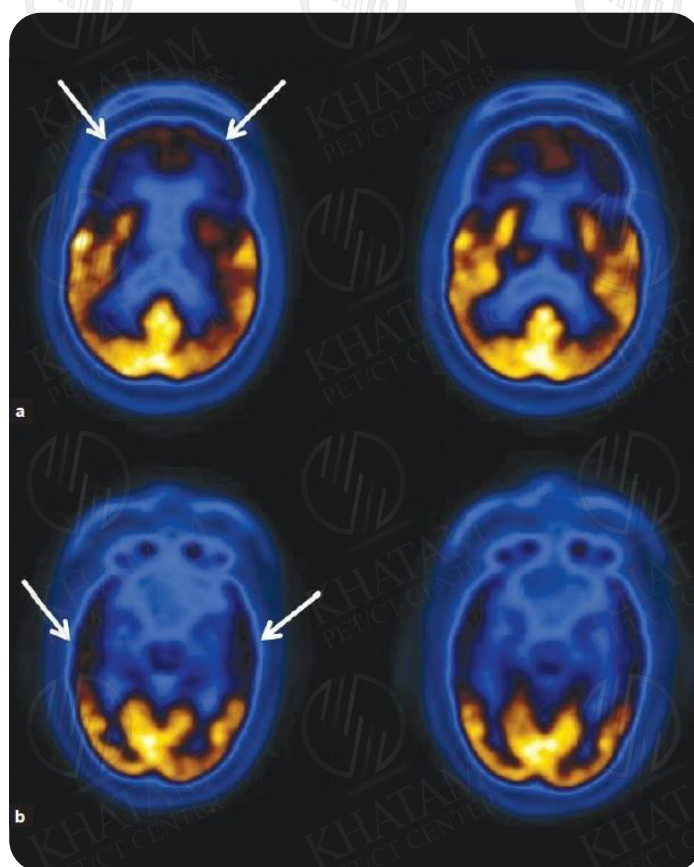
^{18}F -FDG PET images in a 55-year-old female with FTD. Arrows indicate bilateral hypometabolism of the frontal (a) and temporal (b) cortex.
